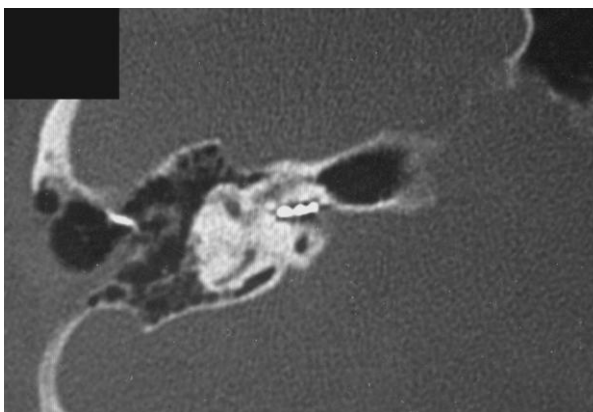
Postoperative CT scan right ear (coronal view): the electrode array penetrates the internal auditory canal
